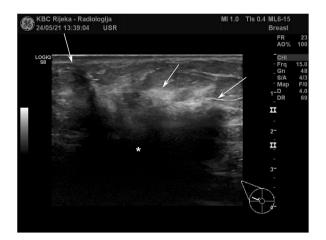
Ultrasonography of the right breast shows a large, homogeneous, hypoechoic mass with multiple lobulations and spiculations and indistinct posterior margins (asterisks), measuring approximately 5 cm. Multiple protrusions into the overlying subcutaneous tissue are seen at the edges of the mass (arrows). The mass causes severe acoustic shadowing in the posterior region.
